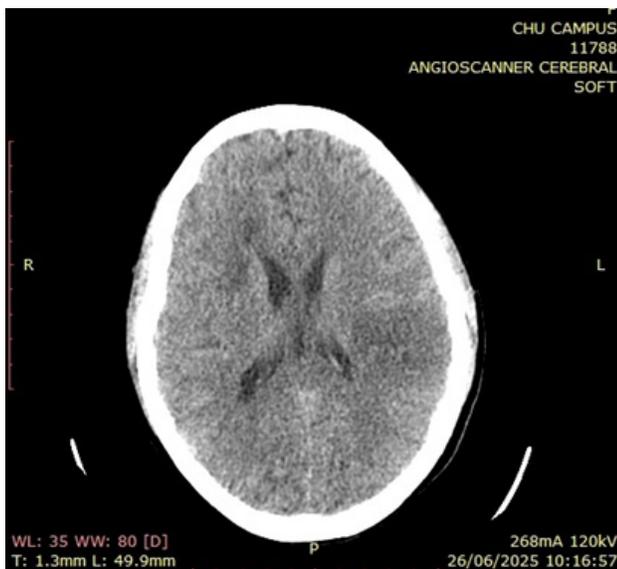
Brain CT scan showing left and right superficial Sylvian infarcts.
